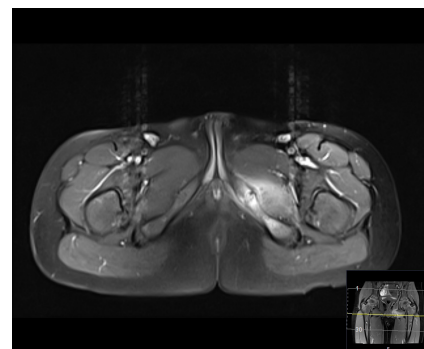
Initial MRI. T1-FS sequence, on the axial plane, after gadolinium administration.
